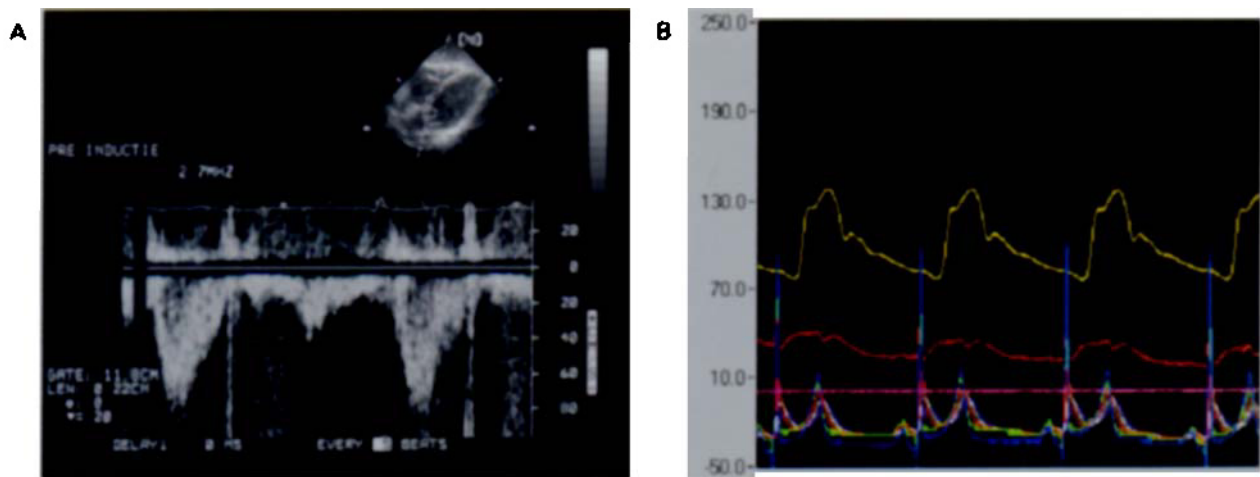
A combination of (A) Doppler flow and (B) invasive haemodynamic monitoring provides important information in the critically ill patient. Automatic acquisition of these signals and digital analysis considerably reduces the workload of the clinician.
